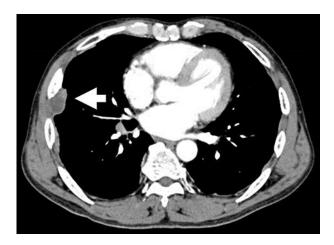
CT image of the chest revealing a mass arising from the right chest wall (arrow).
